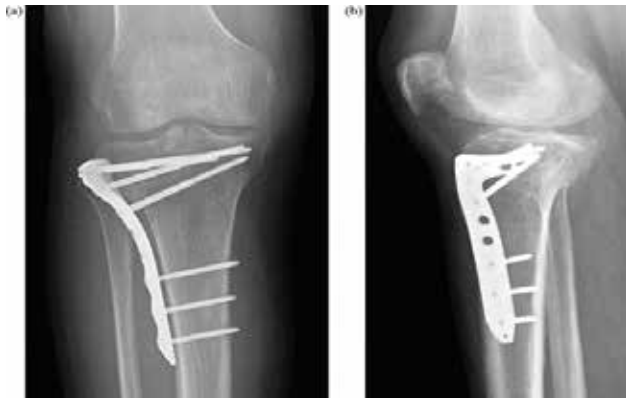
(a) After open reductions postoperative x-ray with locking plate and internal fixations. (b) Lateral X-ray taken 2 years after surgery lateral tibial plateau has a residual deformity.
